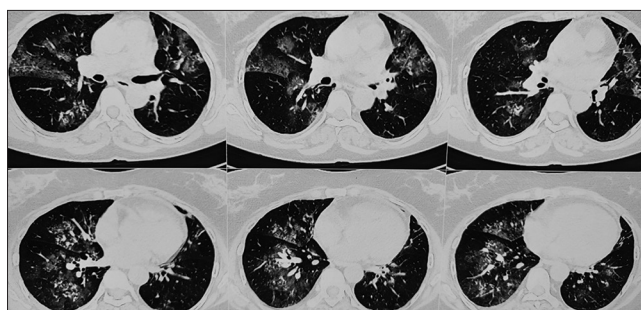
High-resolution computed tomography thorax showing presence of bilateral upper, middle and lower lobe infiltrates with ground glass opacities
